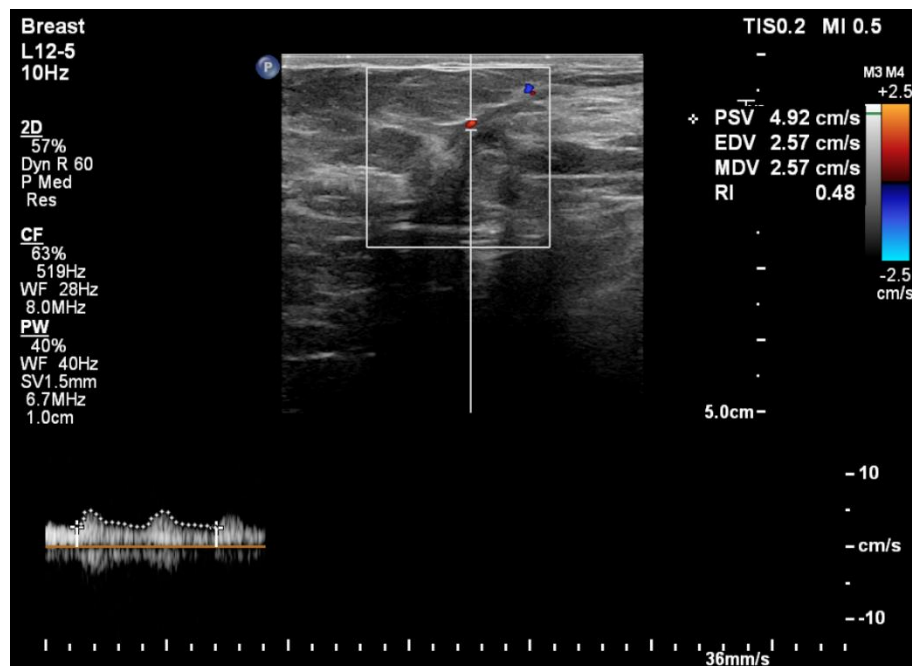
On Doppler interrogation internal vascularity was noted with PSV of 4.92, RI of 0.48 and PI of 0.65.
